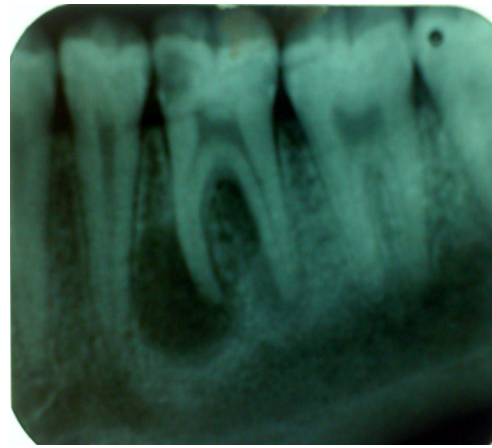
Periapical radiography revealed a radiolucency around the mesial and distal root and in the furcation area of first molar
